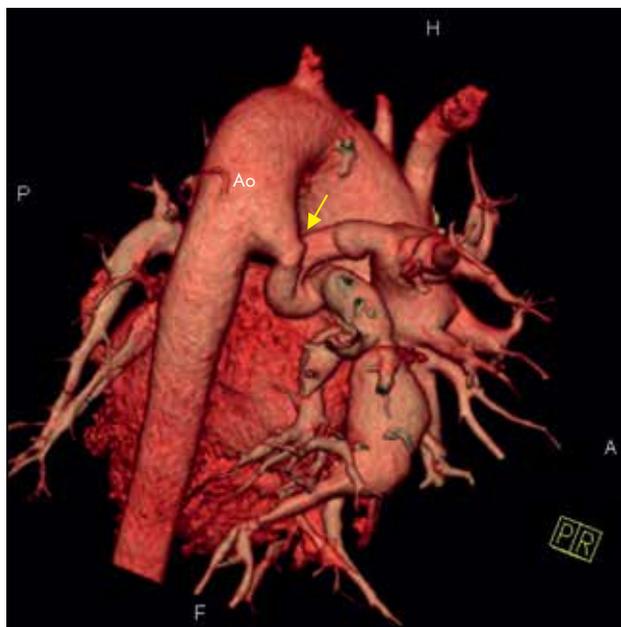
Cardiovascular computed tomography. Three-dimensional reconstruction. Dilatation of ascending aorta (yellow arrow). Ao – aorta
